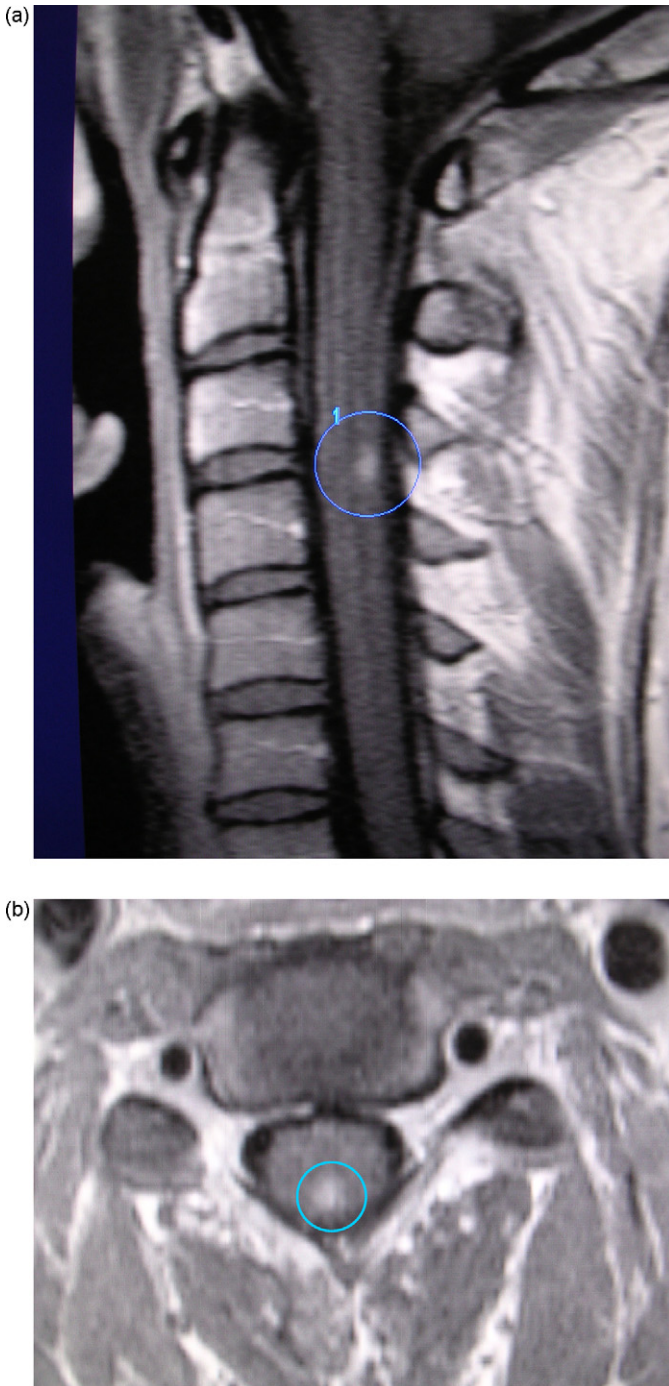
Sagittal (a) and axial (b) T2-weighted MR images show a bilateral hyperintensity in the posterior columns at level C3–C4.
